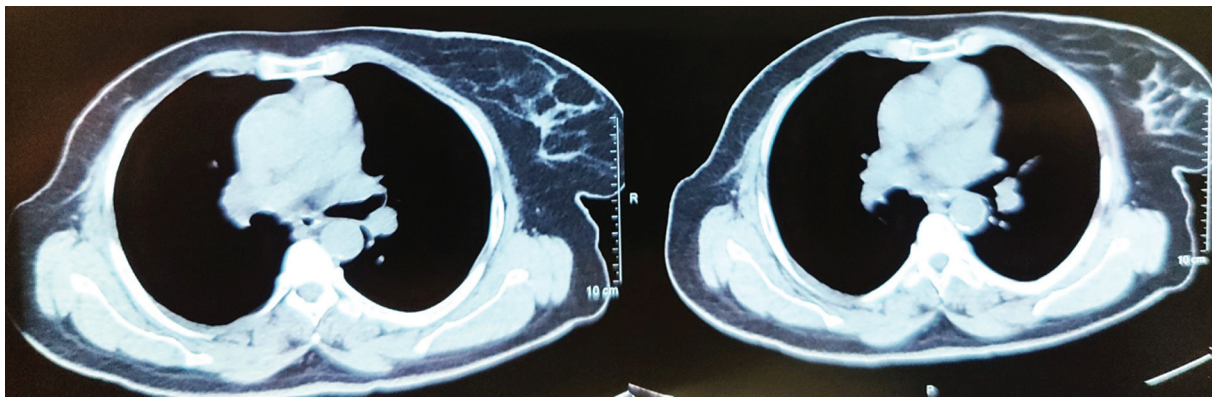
Contrast-enhanced computed tomography (CT) scan showing lesion in the left breast and postop right breast.
